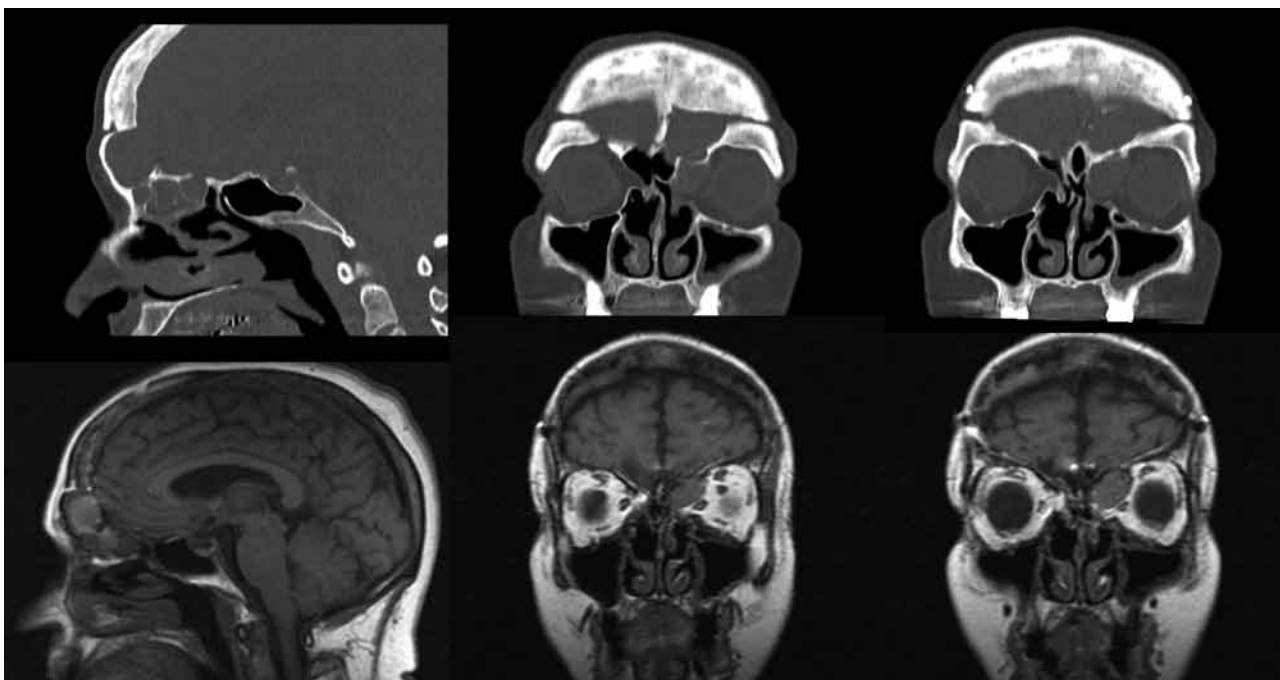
Series of CT scans with accompanying MRI scans demonstrating a frontal and intra-orbital mucocele secondary to previous skull base resection for meningioma.
